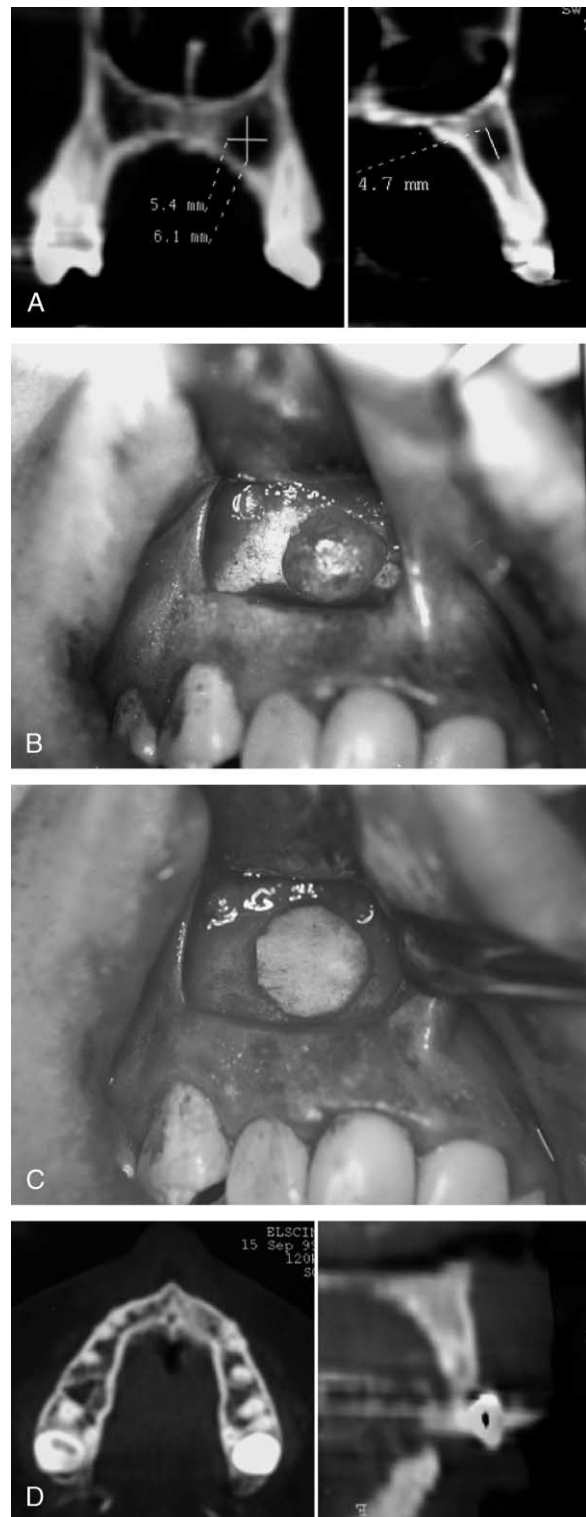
(A) Preoperative CT, shows a cyst in the maxilla. (B) Bone cavity after removal of the cyst. (C) Placement of solvent-dehydrated cortical bone plate. (D) Complete bone healing after 12 months.
